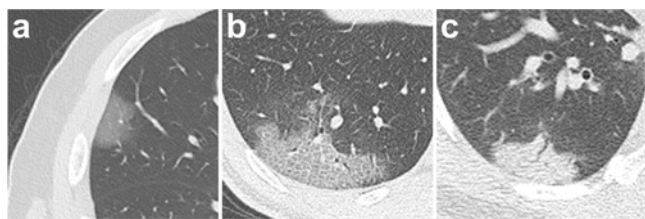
CT chest findings of pneumonia by COVID-19 as seen on trans axial images. (a) Early-stage showing GGO as the typical radiological feature distributed subpleural in the lower lobes (Total CT score 2 ± 2) (31). (b) Progressive stage demonstrating crazy-paving pattern (Total CT score 6 ± 4) (c) Peak stage showing Consolidation (Total CT score 7 ± 4) (30).
